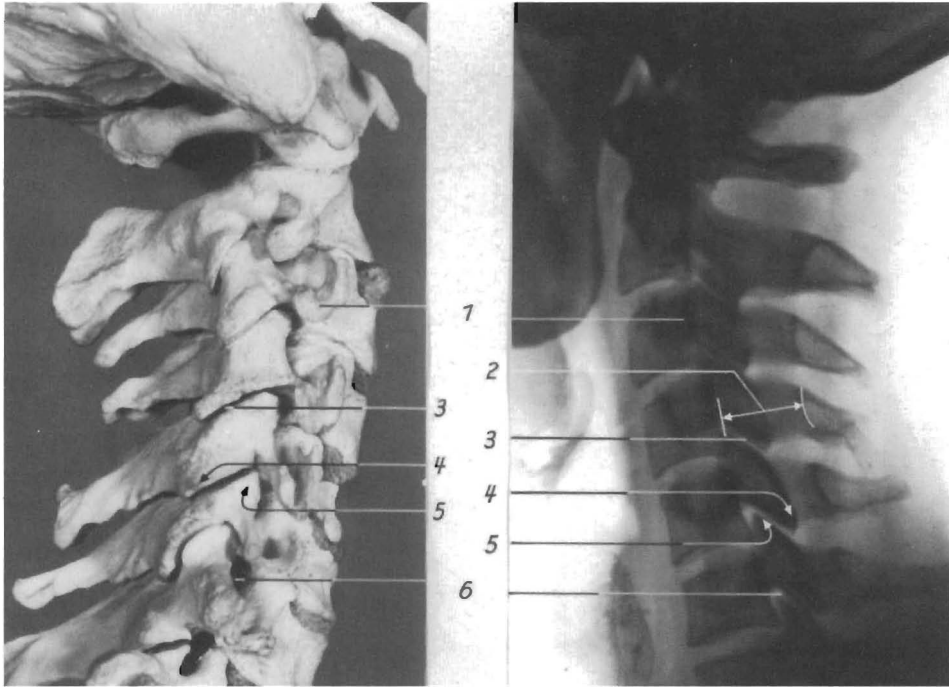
Skeleton of the cervical spine (lateral aspect) compared with the lateral X-ray. 1, Transverse process; 2, width of the spinal canal; 3, joint space; 4, lower articular process; 5, foramen intervertebrale; 6, upper articular process
